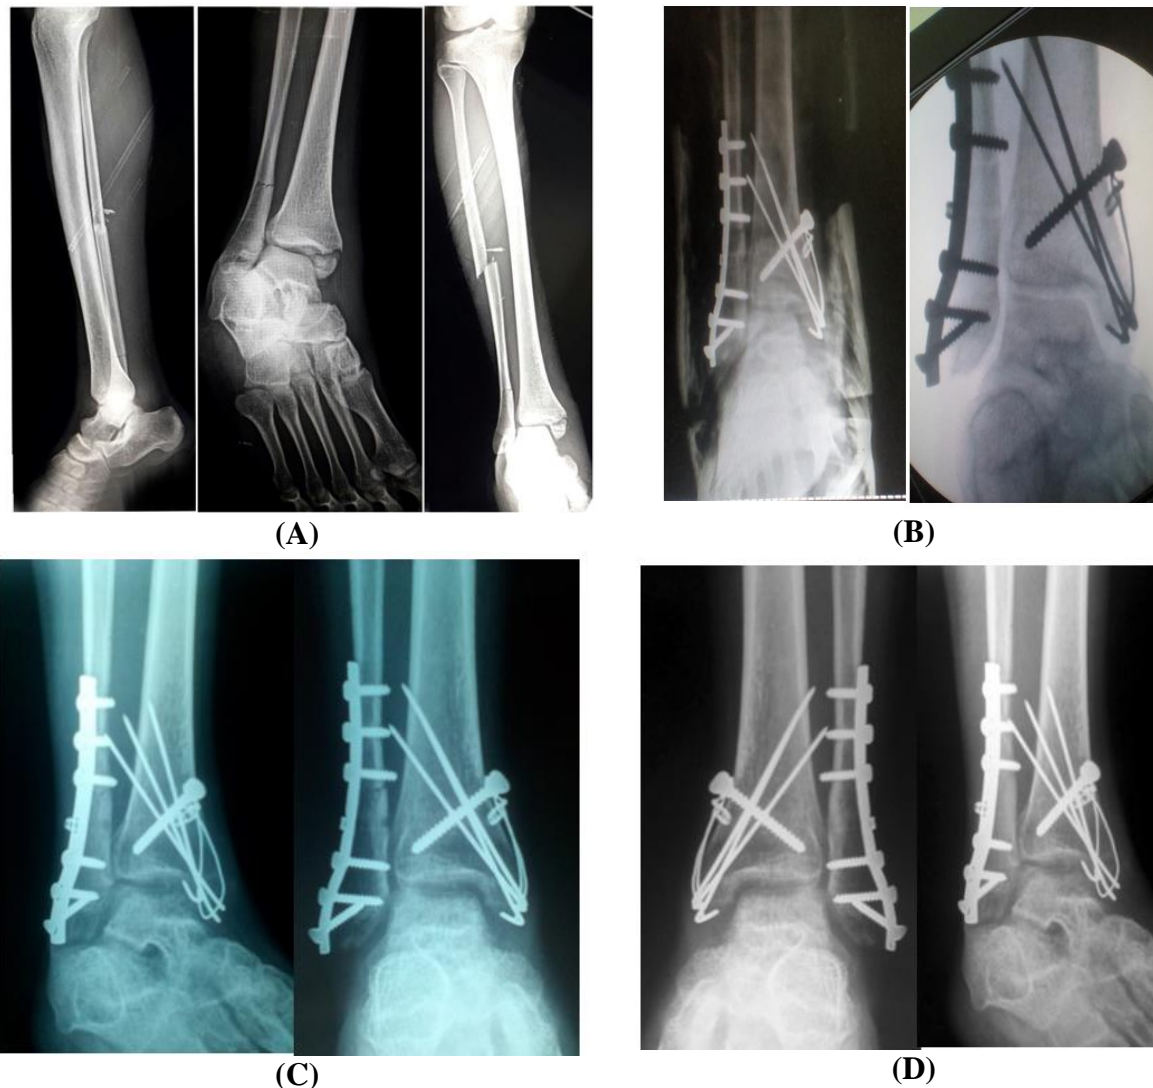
(A): Preoperative X-ray, (B): Post-operative immediately X-ray, (C): Post-operative after 6 weeks, (D):Post-operative after 6 months
